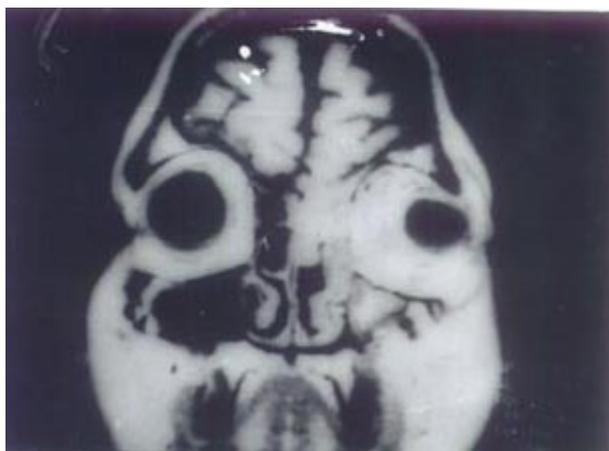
MRI showing left maxillary sinusitis with mas extending into left orbit with erosion of medial wall
